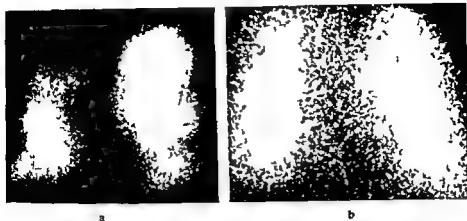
a) Perfusion scintigraphy. Patient with pulmonary embolism. Several defects in both lungs. Anterior projection. b) Ventilation scintigraphy. Same case as in (a). No defects.
